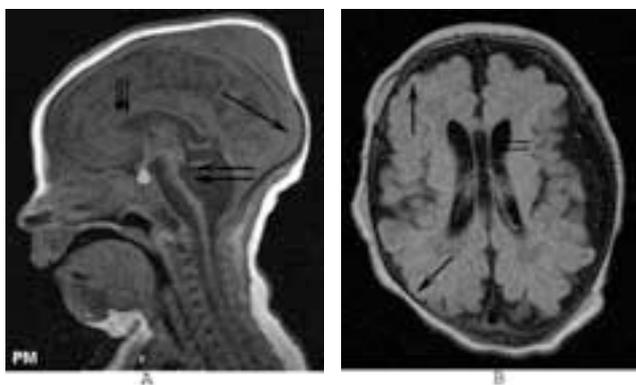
MRI of the brain without gadolinium at 24 hours of life. A: Diminution in size of pons (large double arrows), virtually nonexistent cerebellum with only the superior portion visualized with most of the posterior fossa filled with CSF (large arrow). Anterior portion of the corpus callosum is incompletely formed and the entire corpus callosum is thin (small tripple arrows). B: Ventricles are enlarged with resolving bilateral germinal matrix hemorrhage (double arrows). The sulci and cisterns are prominent and the gyri appear thickened (large arrows).
